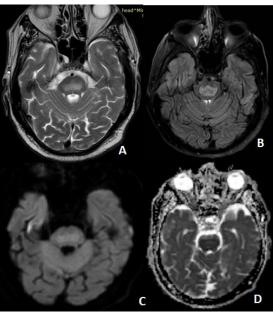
(A): T2WI, (B): FLAIR, (C): DWI, (D): ADC
